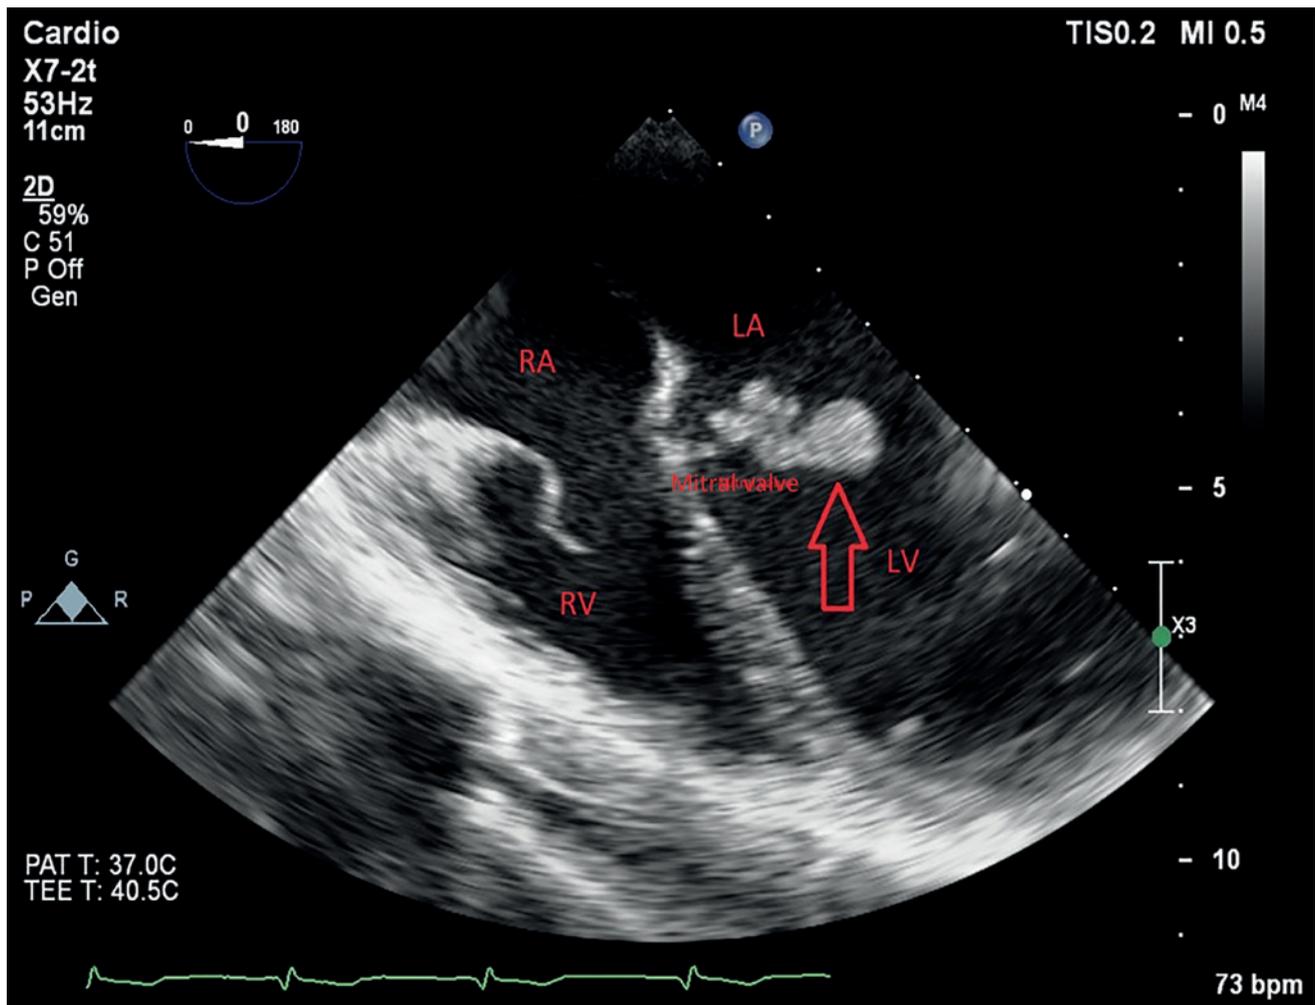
Transoesophageal echocardiography
